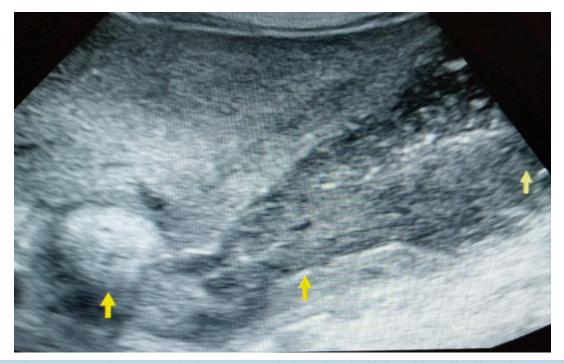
Abdominal ultrasonogram showing an oval echogenic area; calculus in the infundibulum of the gallbladder with surrounding acoustic shadow (left arrow), this measures about 30mm x 30mm in size. The middle arrow shows thick wall while the right show sludge within the gallbladder lumen.
